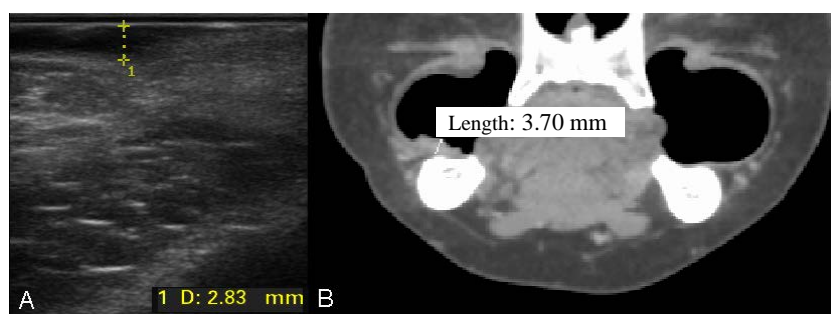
A) IOUS of oral cavity carcinoma (OCC) localized on the buccal mucosa with measured DOI. Note the hypoechoic, plaque lesion with an unsharp border towards the deeper buccal tissues. B) Contrast-enhanced CT in coronal reformation and in distension technique (inflated cheeks) presenting the DOI measuring of well-opacified OCC, localized on the buccal mucosa. For abbreviations, see Figure 1.
